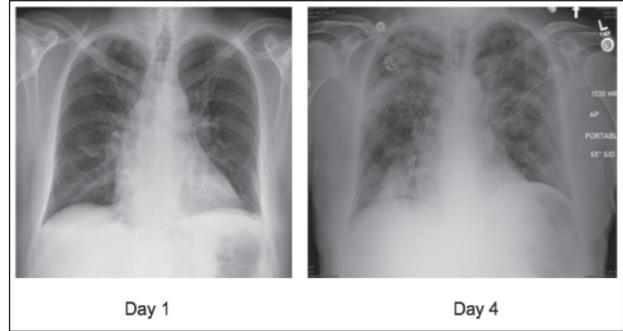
Anterior-view chest x-ray from Day 1 and Day 4.
